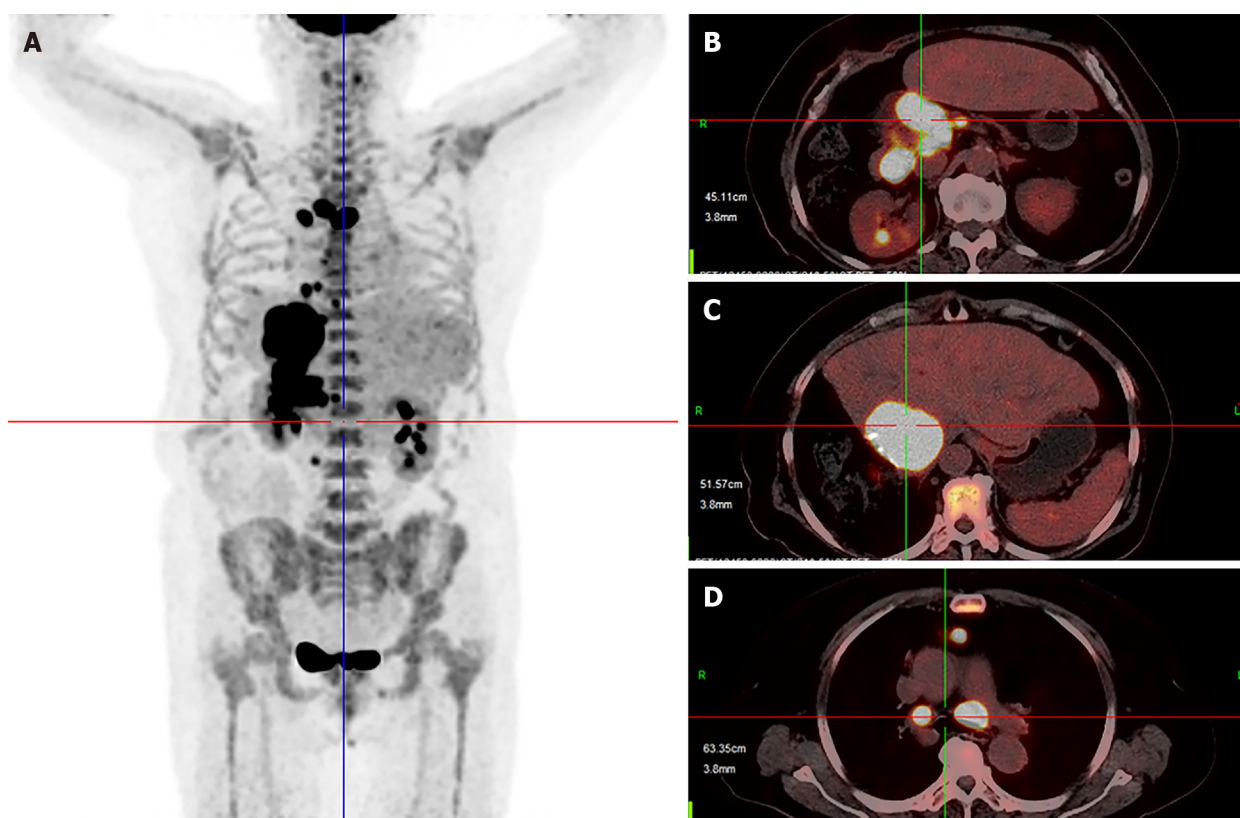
Positron emission tomography-computed tomography. A-D: Multiple metastases located in the liver, mediastinum and peritoneum.
